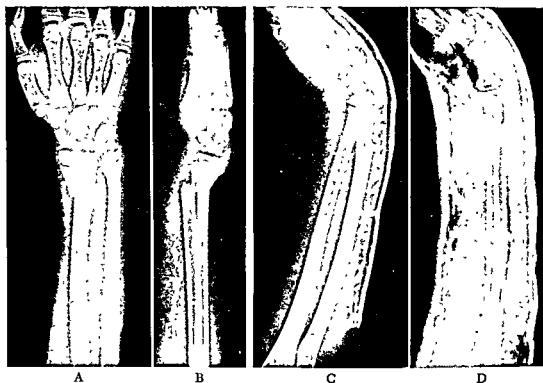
Fracture in the distal fourth of the radius and ulna in a child. A and B, Views showing displacement of radius and angulation of ulna. C, Lateral x-ray film, showing reduction and the dorsal plaster splint. D, Lateral view, showing good reduction and circular cast which included the splint.
